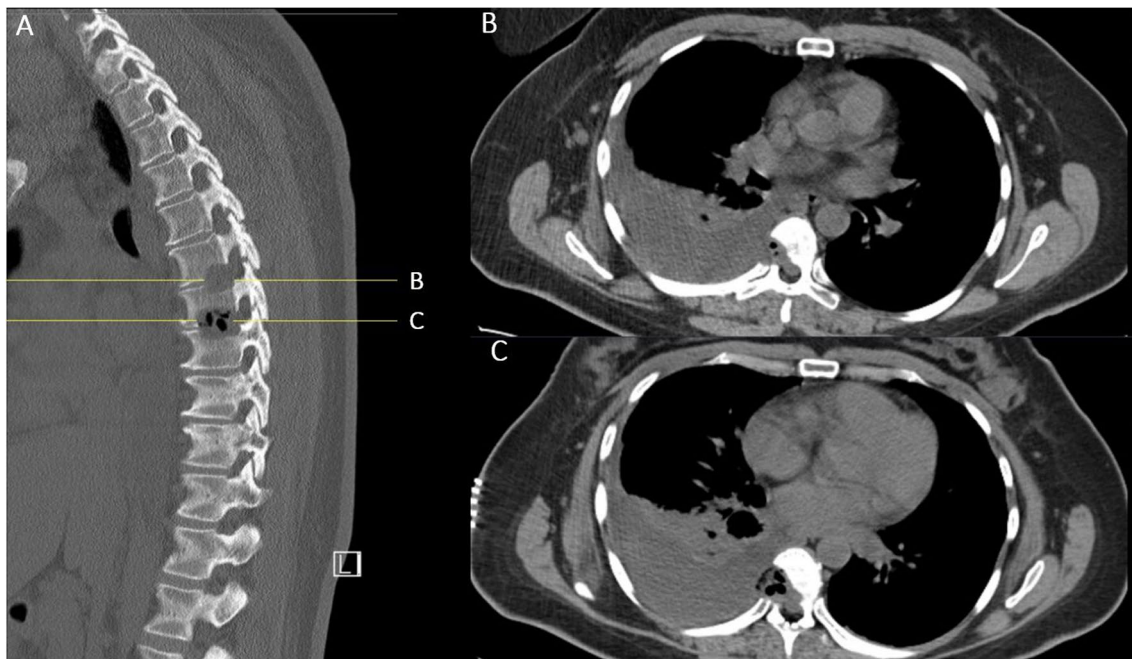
Computed tomography (CT) image obtained on the second day after surgery. A. Paramedian sagittal image in bone setting showing the transcorporeal corridors on levels Th6-Th7 and Th7-Th8. B and C.
